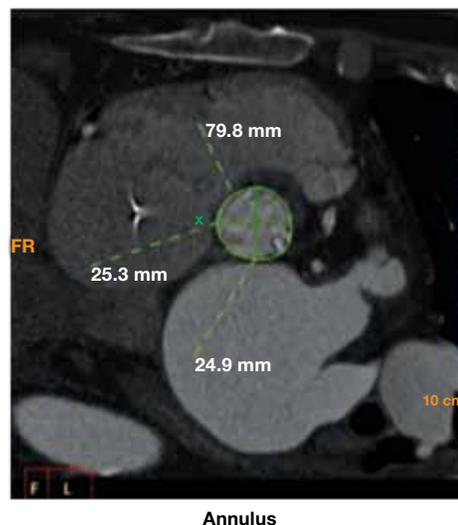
Aortic annulus measurement by CTA. The annulus is defined at the transverse plane immediately below the lowest insertion point of the aortic leaflets as assessed by double oblique transverse images of the aortic root at the level of the basal ring. Measurements are taken from the systolic phase of the cardiac cycle when the valve is maximally opened. The perimeter of the basal annulus is traced manually. The measurements are performed in two planes because the annulus is usually elliptical in shape. First the major diameter through the center of the annulus is measured. The minor diameter is measured by tracing perpendicularly to the major diameter and through the center of the annulus. Note in this case, that the basal ring is fairly circular.
